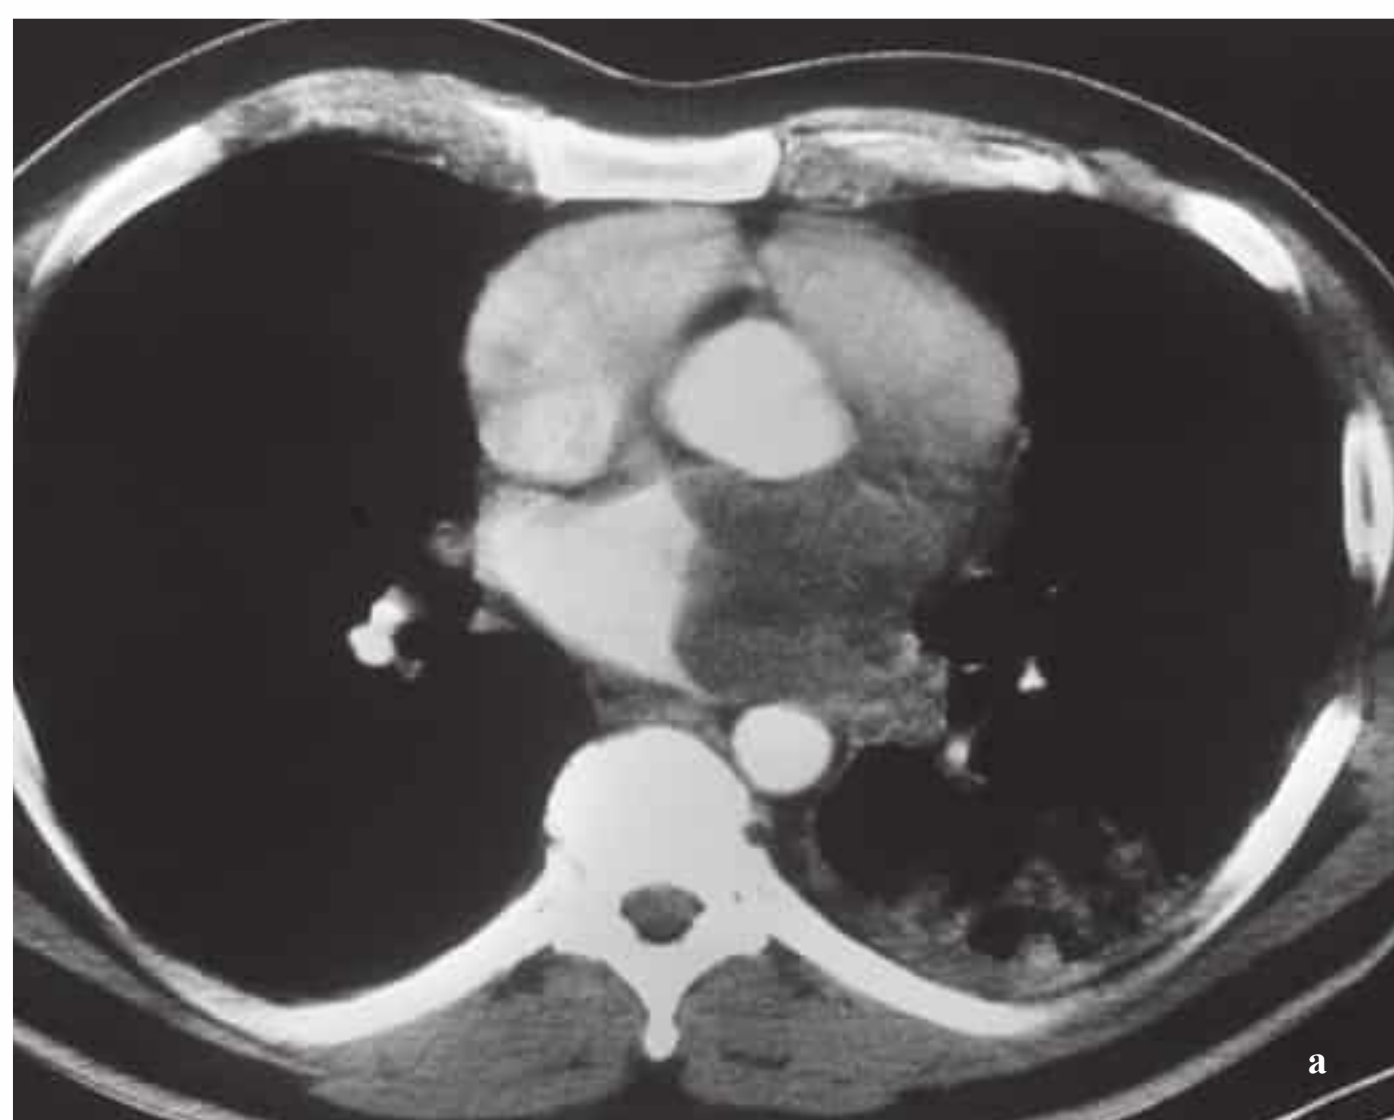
a, b Tumor of the pulmonary vein (CT and MRI). CT (a) and MRI (b) of a pulmonary vein sarcoma extending into the left atrium. The relationship of the tumor to the other cardiac chambers and vessels is clearly demonstrated by CT. Invasion of these structures is difficult or impossible to detect, however. Coronal MRI (HASTE) provides assessment of invasion of adjacent structures by clear delineation of different signal intensities.
